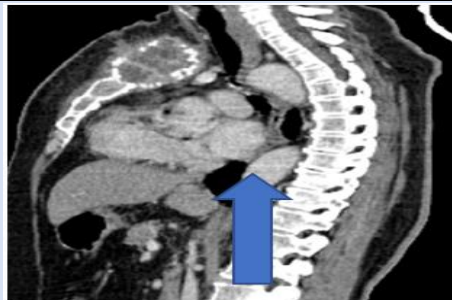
Sagittal cut of an injected CT-scan, focused on the sternal mass.
